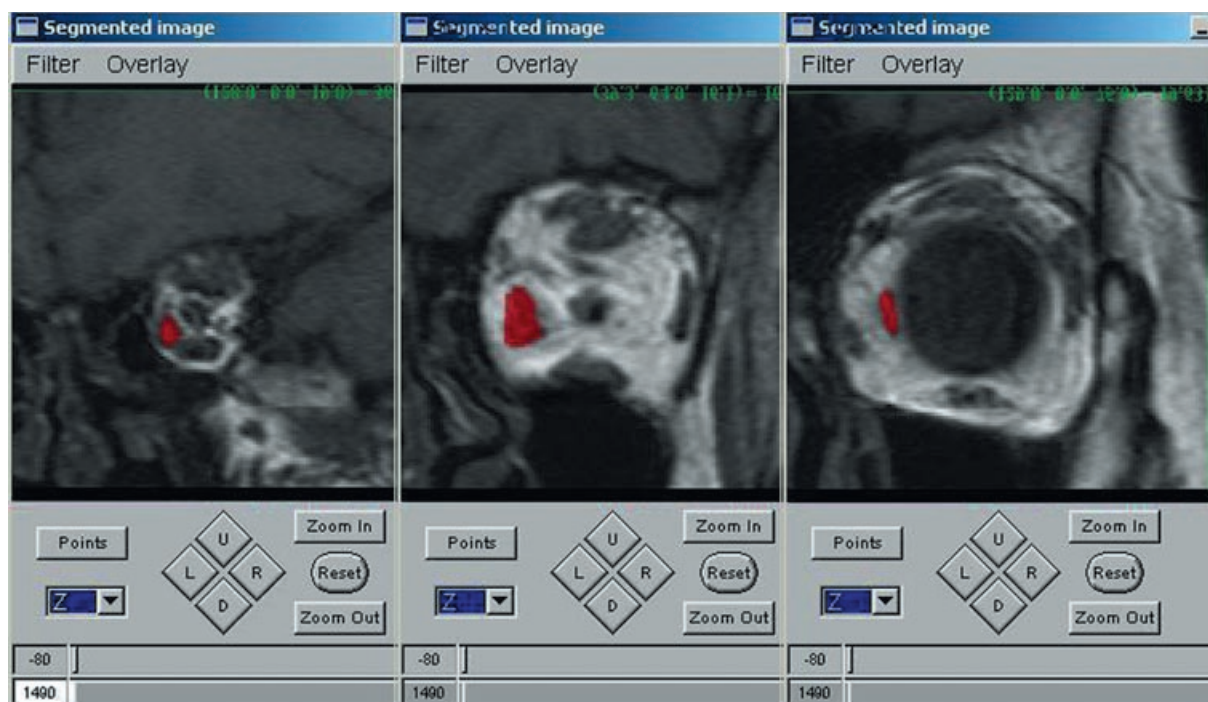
Muscles' volume calculation by NSI application; fitting the area inside the contour to the chosen element of MR images.
